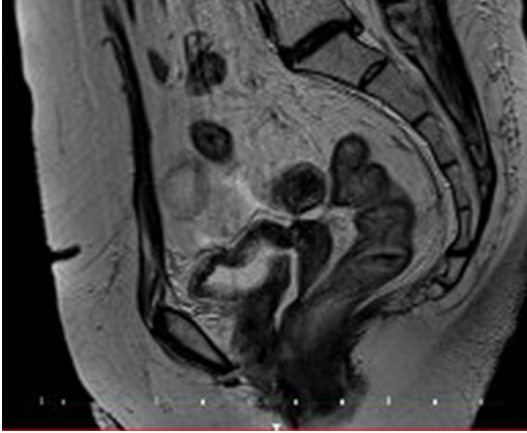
MRI findings of patient 1.
